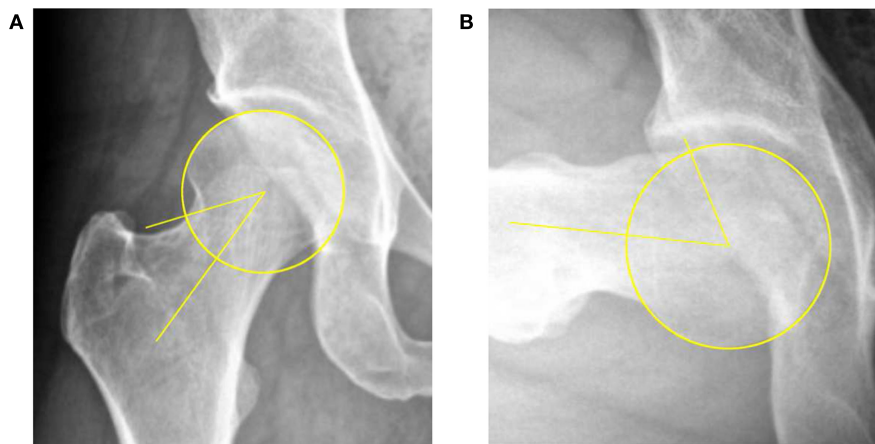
Determination of head–neck offset by measurement of the α angle on AP (A) and 90°-Dunn lateral (B) radiographs.
